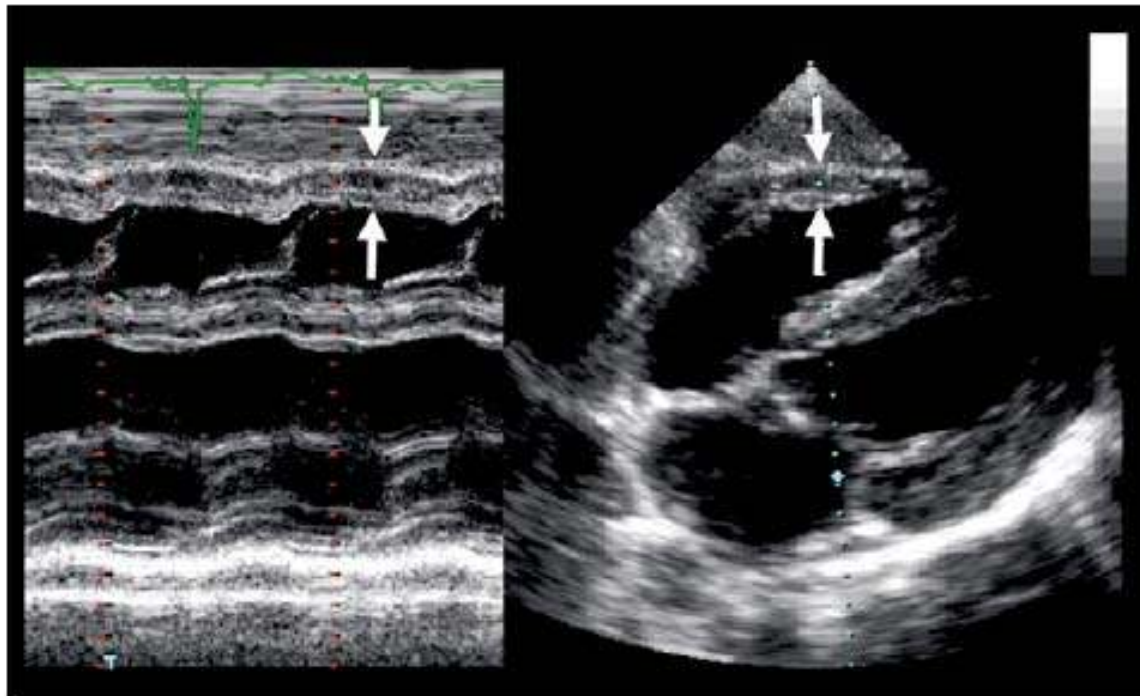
Methods of measuring right ventricular wall thickness (arrows) from an M-mode echo (left) and a subcostal transthoracic echo (right).
